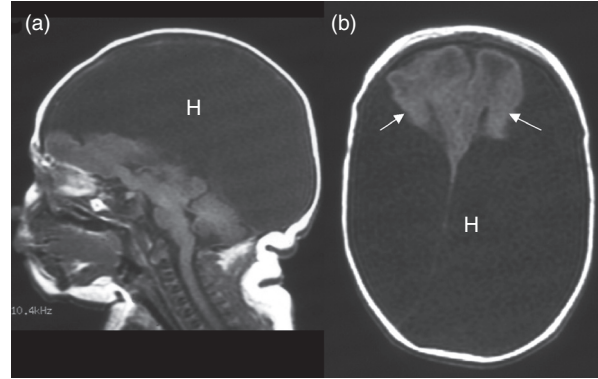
Hydranencephaly on (a) sagittal and (b) axial T1 MRI. Only a small portion of cortex is present frontally (arrows).
